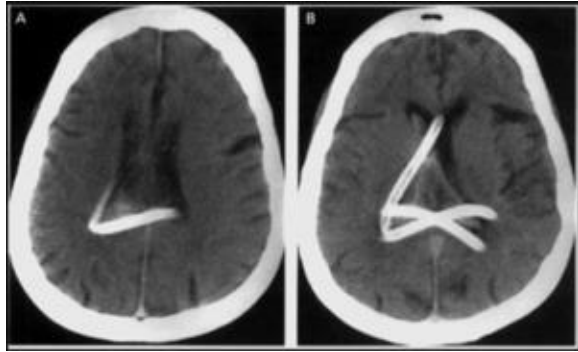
axial CT of a patient with Basal skull fracture show the presence of nasogastric tube in the brain, this was the result of malpractice
